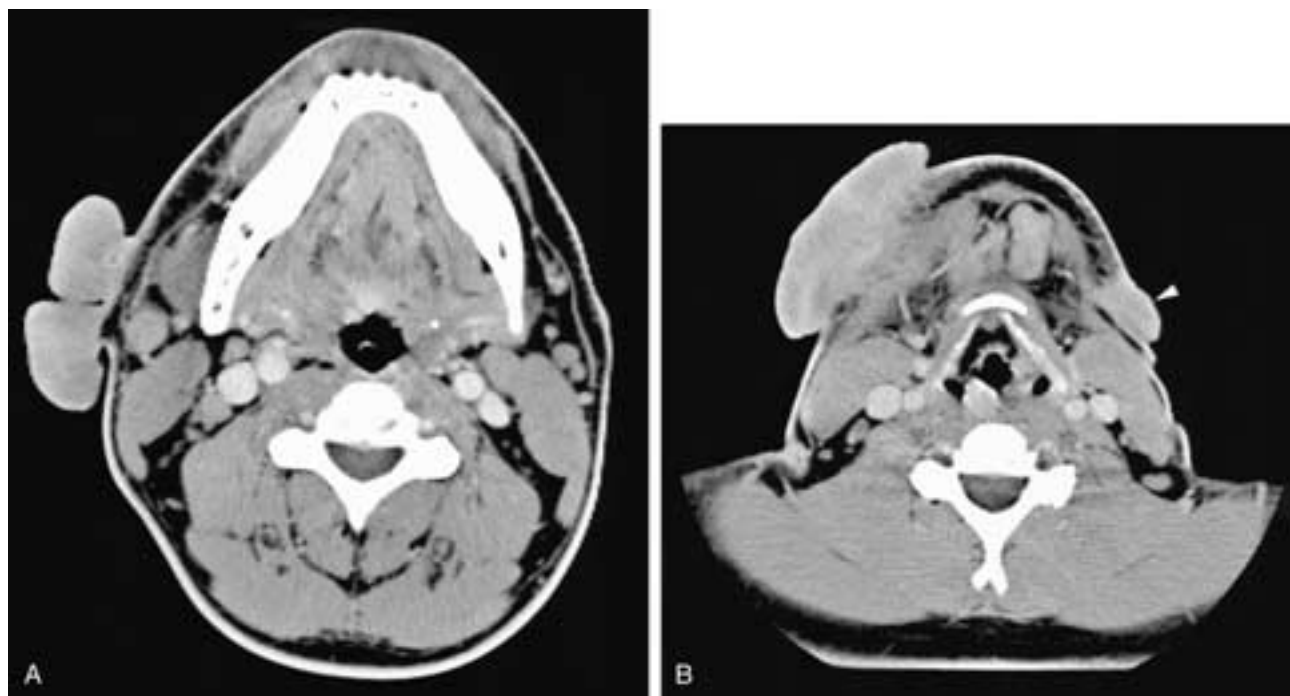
Axial contrast-enhanced cranial (A) and caudal (B) CT scans show a huge keloid in the right neck. Although there is some subcutaneous extension along the scar line, the vast majority of the mass is superficial to the skin. A second smaller keloid is present in the left neck (arrowhead in B). Incidentally noted is level I reactive adenopathy.
